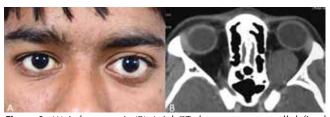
(A) Left proptosis (B) Axial CT demonstrates a well-defined isodense intraconal lesion with optic foramen widening which on biopsy was proven to be optic nerve glioma.
